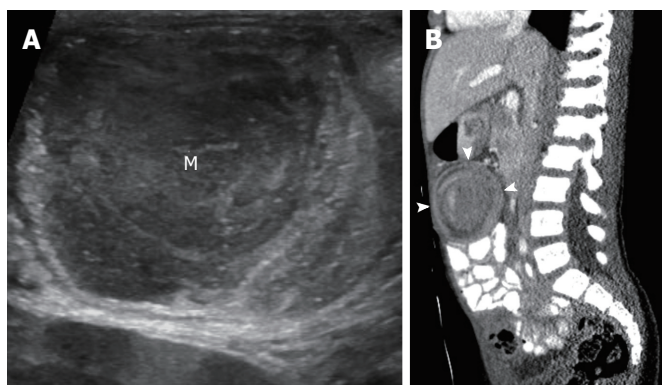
Burkitt lymphoma. Eight-year-old boy presented with weight loss and abdominal pain. Abdominal ultrasound showed ileocolic intussusception with soft tissue mass (M) as a lead point (A). Bilateral renal masses were also present (not shown). Sagittal reformatted computed tomography image shows ileocolic intussusception (B, arrowheads). Diagnosis was confirmed with biopsy.
